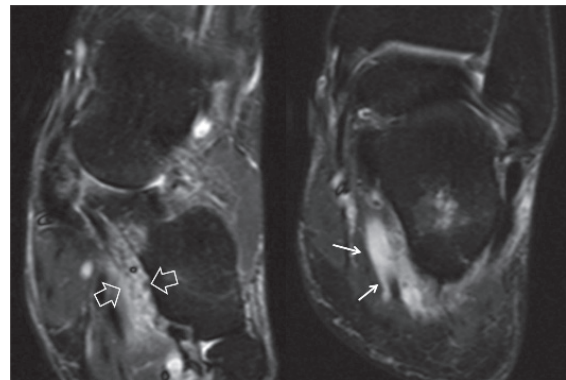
Coronal STIR MR images, at the level of midfoot (left) and hindfoot (right) showing the varicose lateral plantar vein (arrows) and the oedematous quadratus plantae muscle (open arrows).
